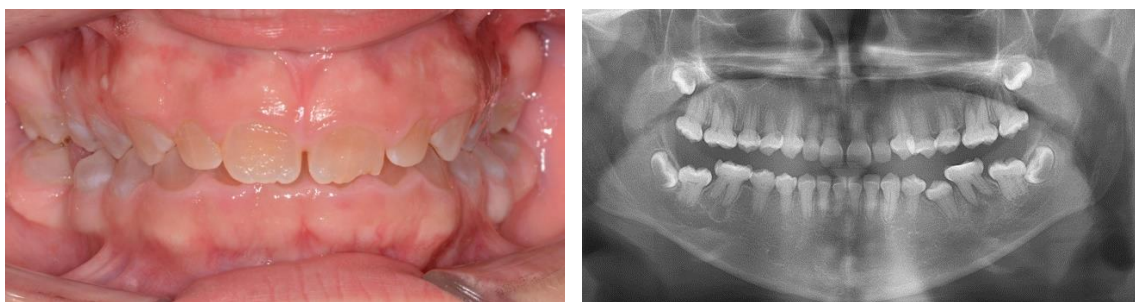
Clinical and radiographic findings in an 11-year-old boy with a severe form of DGI-II.
